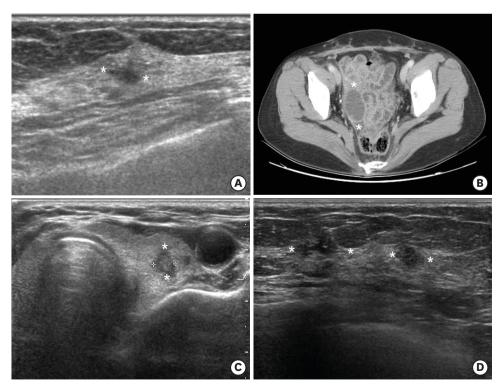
Ultrasonography findings of the lesions in the ovary, breasts, and thyroid. (A) Ultrasonograph of a left breast lesion. (B) Computed tomography of a right ovarian tumor. (C) Ultrasonograph of a left thyroid lesion. (D) Ultrasonograph of right breast lesions. *Indicates the lesion in each organ.
